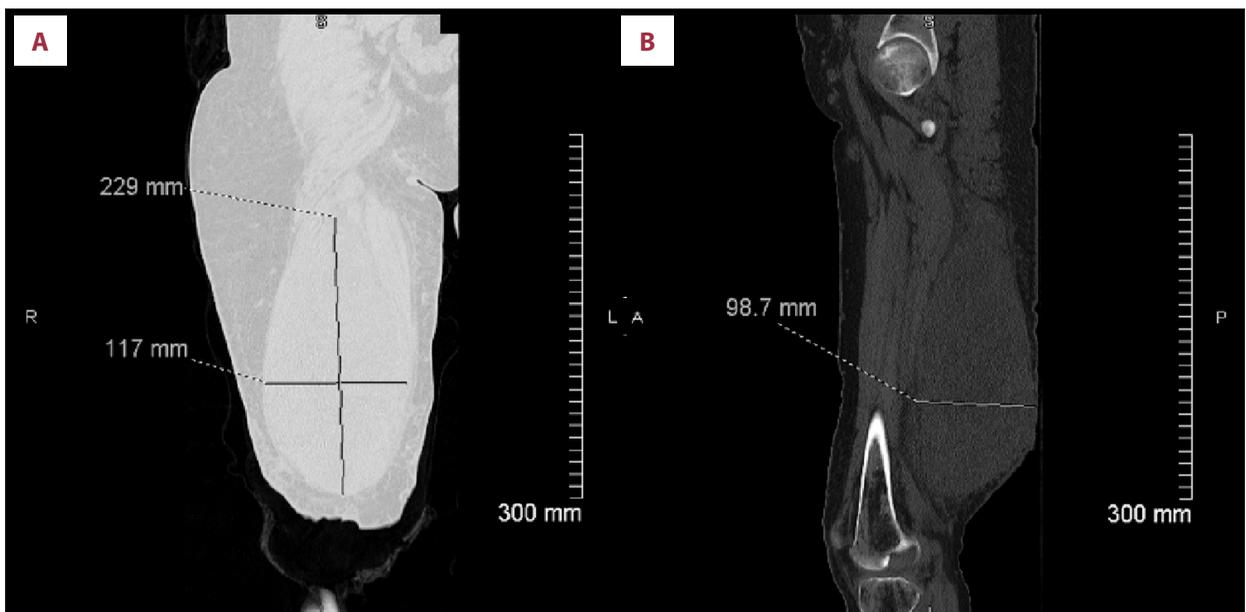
Anterior (A) and lateral (B) CT scans of the tumor demonstrating its large size prior to excision.
